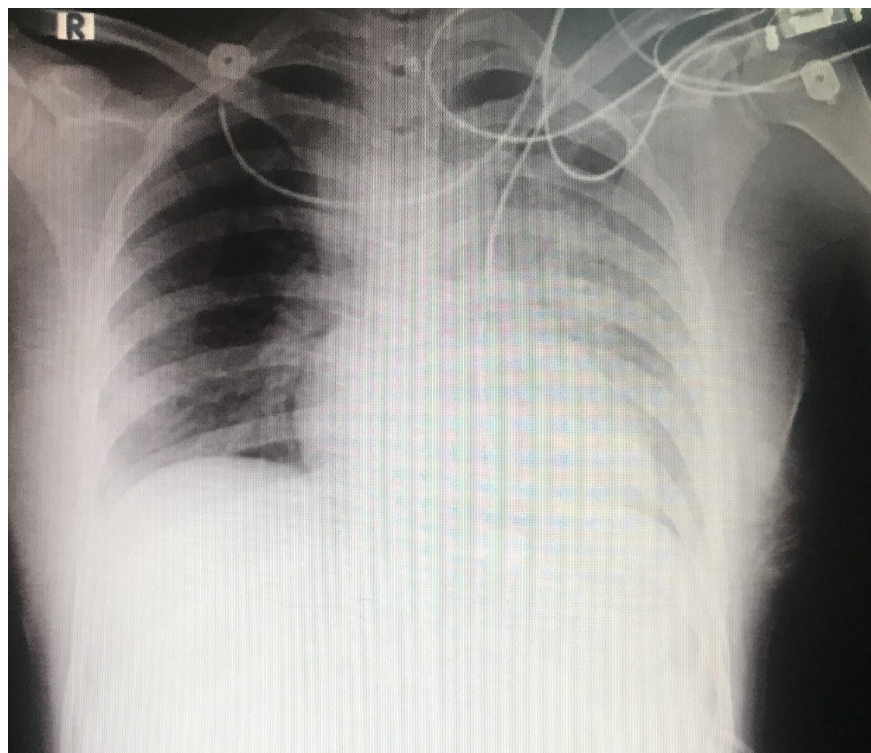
Patient chest X-Ray
